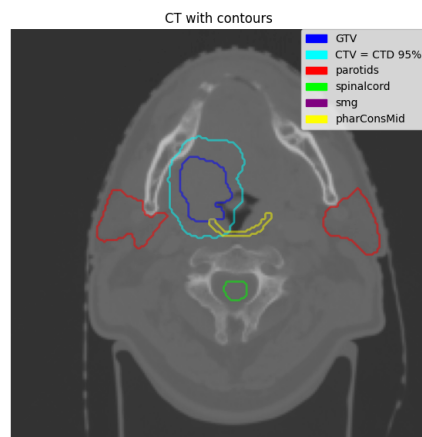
Contours in the head and neck CT.
